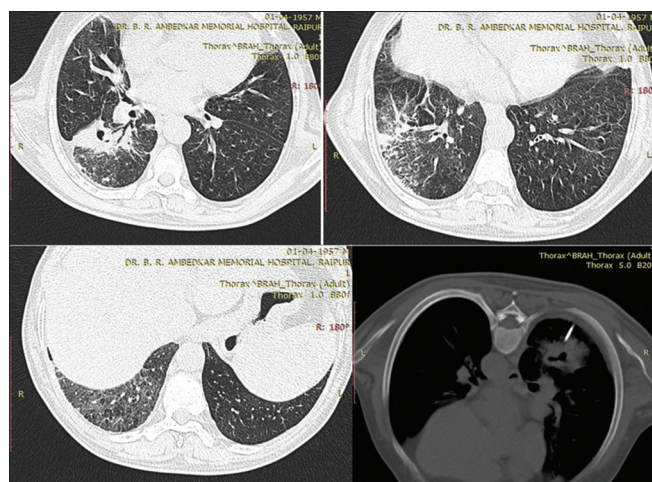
Axial HRCT images through lower lobes showing consolidation and ground-glass opacity with reticular opacities. Few bronchiectatic changes also noted. Last image showing computed tomography-guided biopsy from the lesion. Biopsy demonstrated usual interstitial pneumonia
